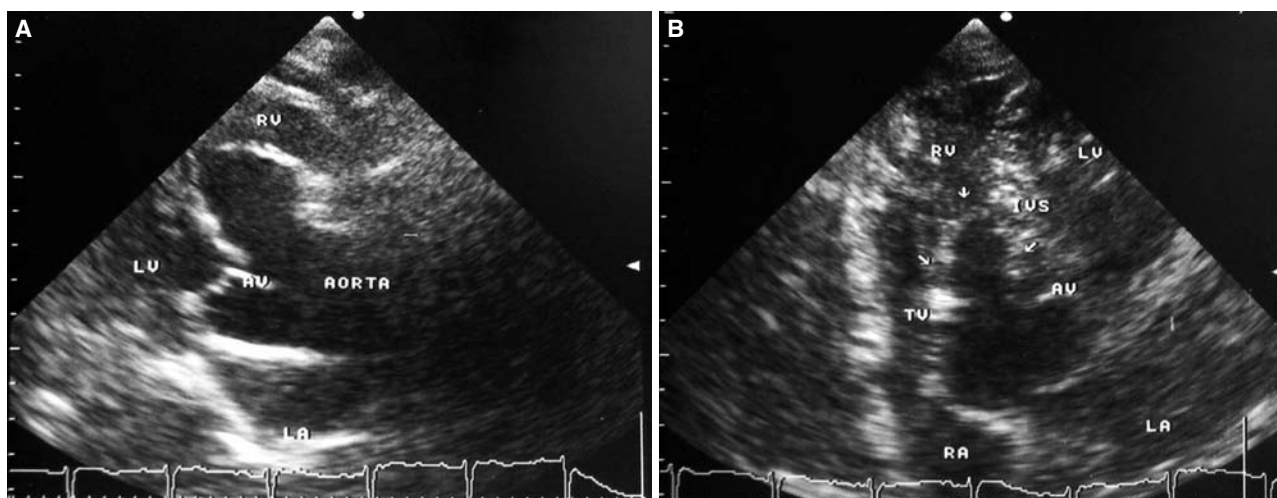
An unruptured right sinus of Valsalva aneurysm is seen in the (A) parasternal long-axis and (B) apical four-chamber views. AV: Aortic valve; IVS: Interventricular septum; LA: Left atrium; LV: Left ventricle; RA: Right atrium; RV: Right ventricle.
